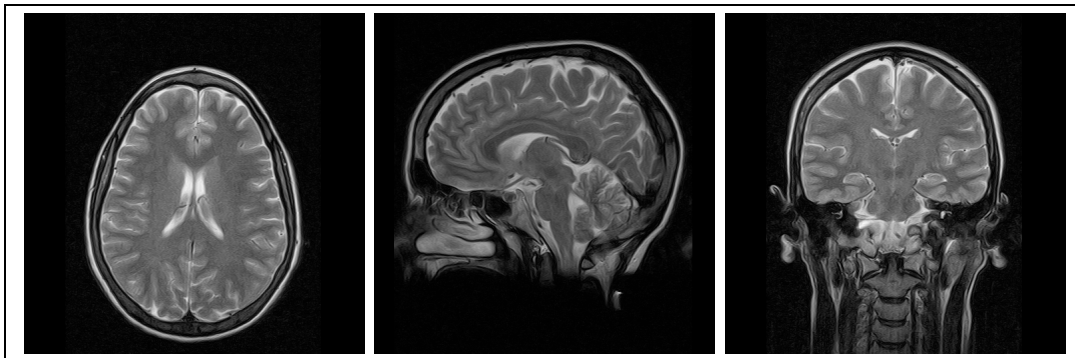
Different views of MR images showing the same brain. From left to right: axial, sagittal and coronal views. MR type is flair in all case.
